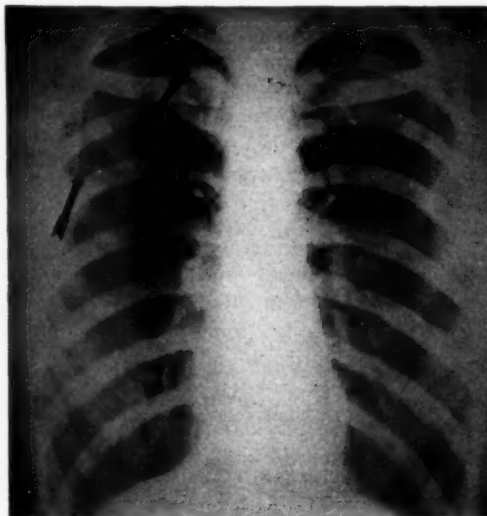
M. H. B. X-ray film of the chest taken September 21, 1925, of a recent graduate in nursing, aged 26. No history of exposure to tuberculosis before entering school of nursing, June 22, 1922. Shows shadows in the right first and second interspaces, which proved to be first infection type of tuberculosis.
